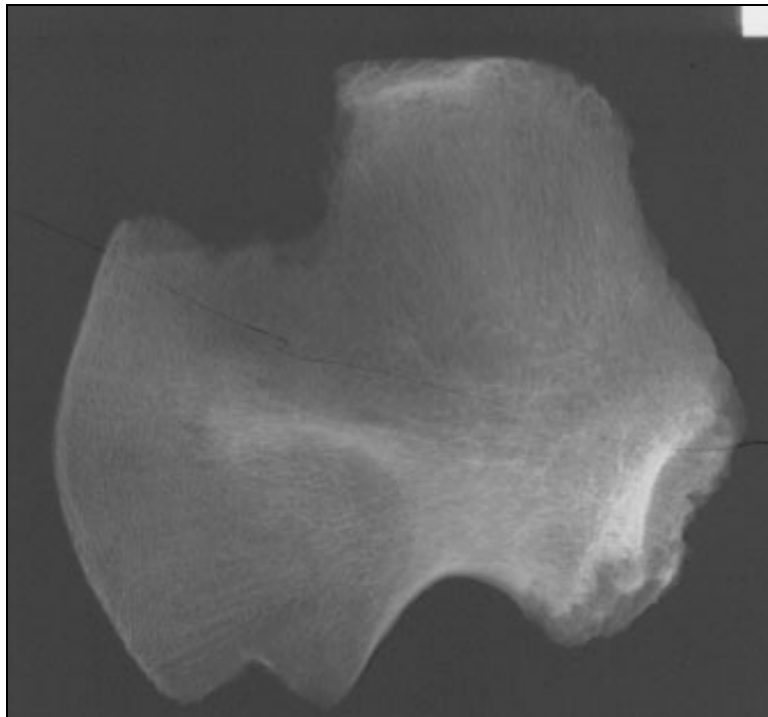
Radiograph of ilium showing no lines #76-73.
